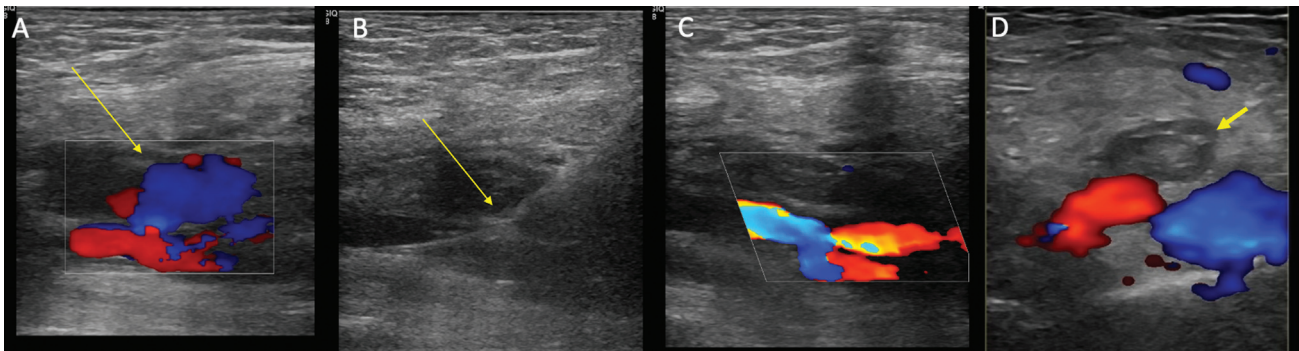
(A) Short neck pseudoaneurysm arising from common femoral artery (CFA; yellow arrow). (B) Percutaneous ultrasound-guided wire access into the CFA through neck of pseudoaneurysm (yellow arrow). (C) Thrombosed pseudoaneurysm after successful deployment of the suture. (D) Follow-up ultrasound doppler after 3 days showing thrombosed pseudoaneurysm (yellow arrow).
